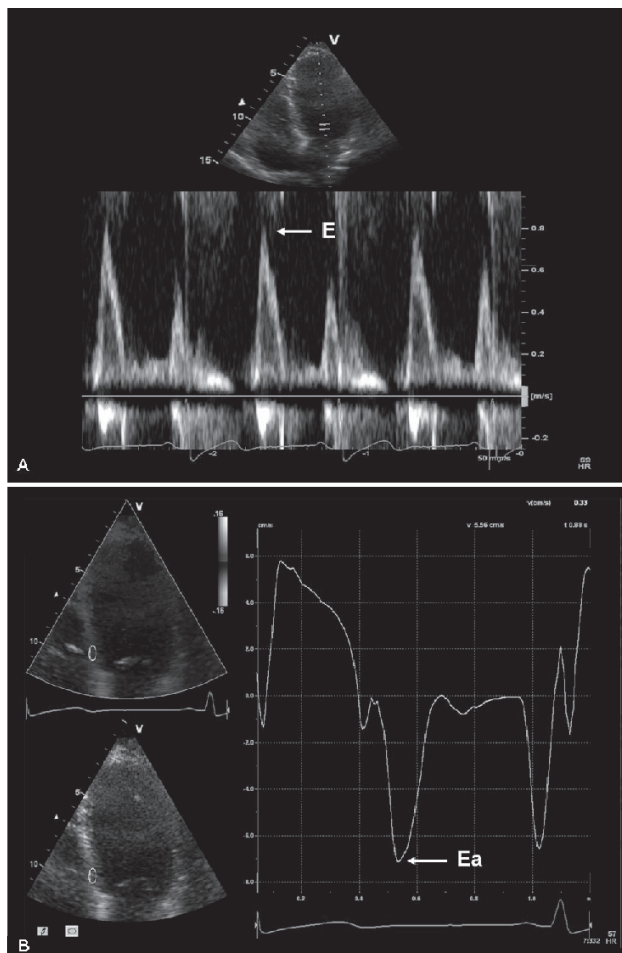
Evaluation of diastolic function with 2-dimensional (2D) echocardiography using tissue Doppler imaging (TDI). 2D echocardiographic assessment of pulsed-wave Doppler of early (E) transmitral velocity (cm/s) (panel A) and early diastolic peak mitral septal tissue velocity (cm/s) (Ea) at basal septal segment by TDI (panel B). The E (white arrow, panel A) and Ea (white arrow, panel B) were 0.80 m/s and -7.1 cm/s. Accordingly, the E/Ea was 11.27.
